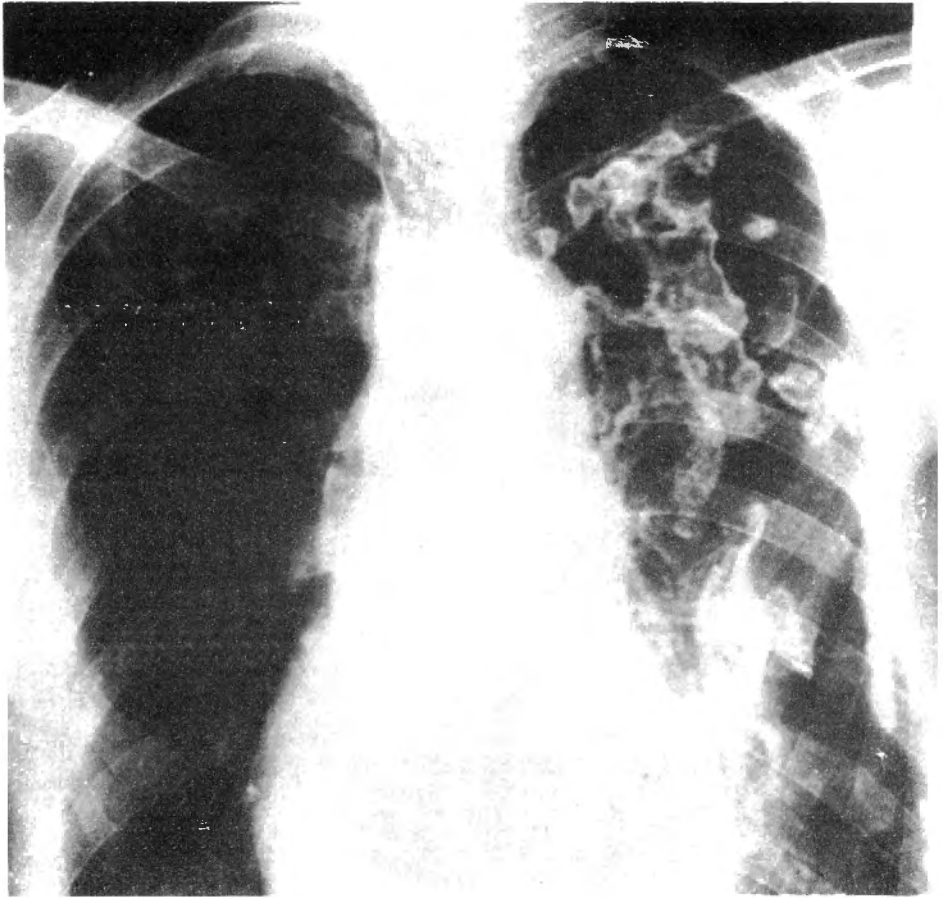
Radiograph showing bilateral diffuse calcified pleural plaques with pleural thickening. Case from Sarhıdır.
